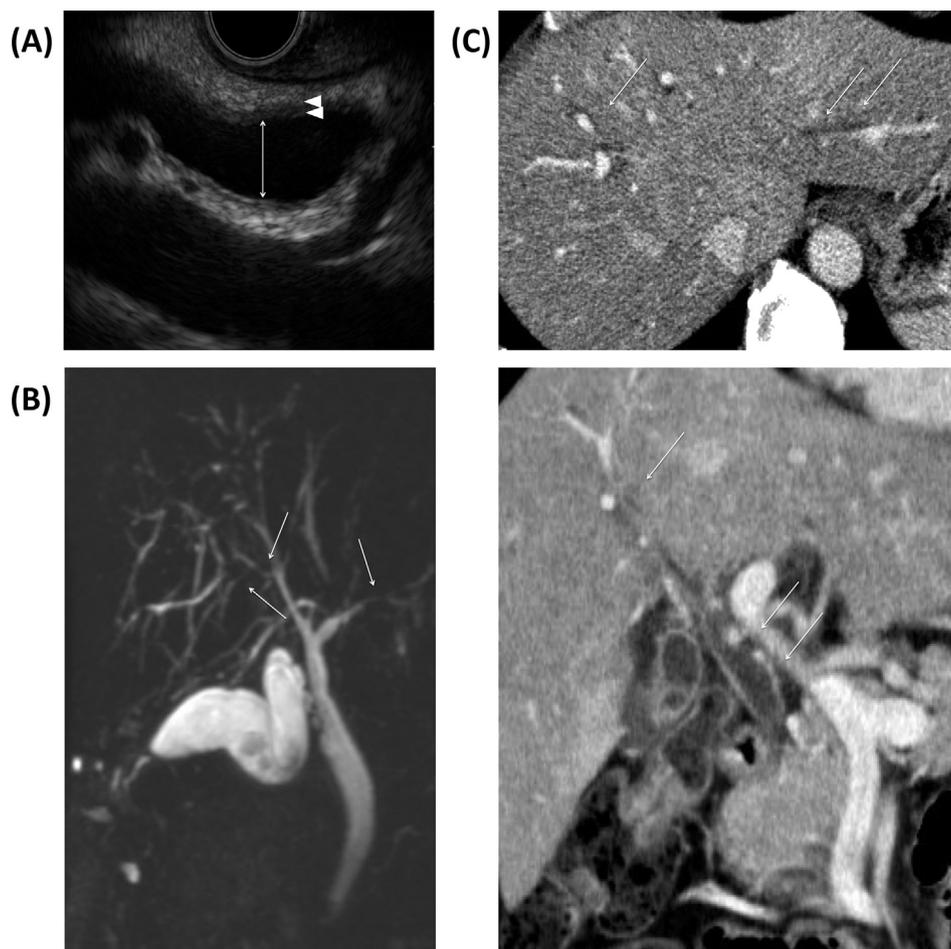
(A) Endoscopic ultrasound showed wall thickening (1.6 mm, arrowheads) and slight dilation (10.8 mm, arrow) of the extrahepatic biliary duct. (B) Magnetic resonance cholangiopancreatography showed diffuse and multiple strictures (arrows) and slight dilation of the intrahepatic biliary ducts. (C) Computed tomography showed wall thickening of the extrahepatic biliary duct as well as diffuse strictures and dilation of the intrahepatic biliary ducts (arrows).
